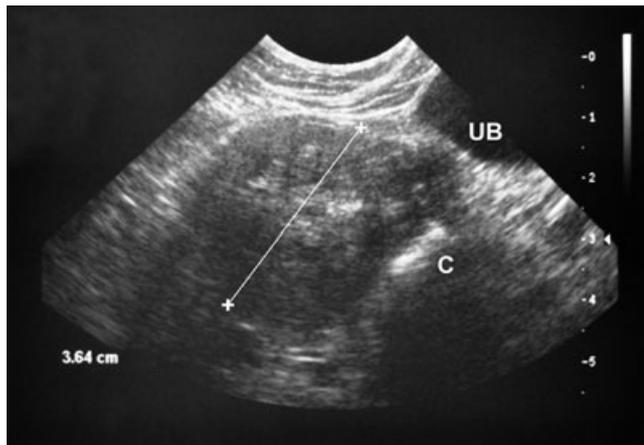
Transverse ultrasonographic image of the caudal abdomen. The heterogeneous mass 3.6 cm in diameter ventral to the colon (c) and dorsal to the urinary bladder (UB) is the uterine stump. Cytological examination of fine-needle aspiration biopsies of the mass revealed septic, purulent inflammation
